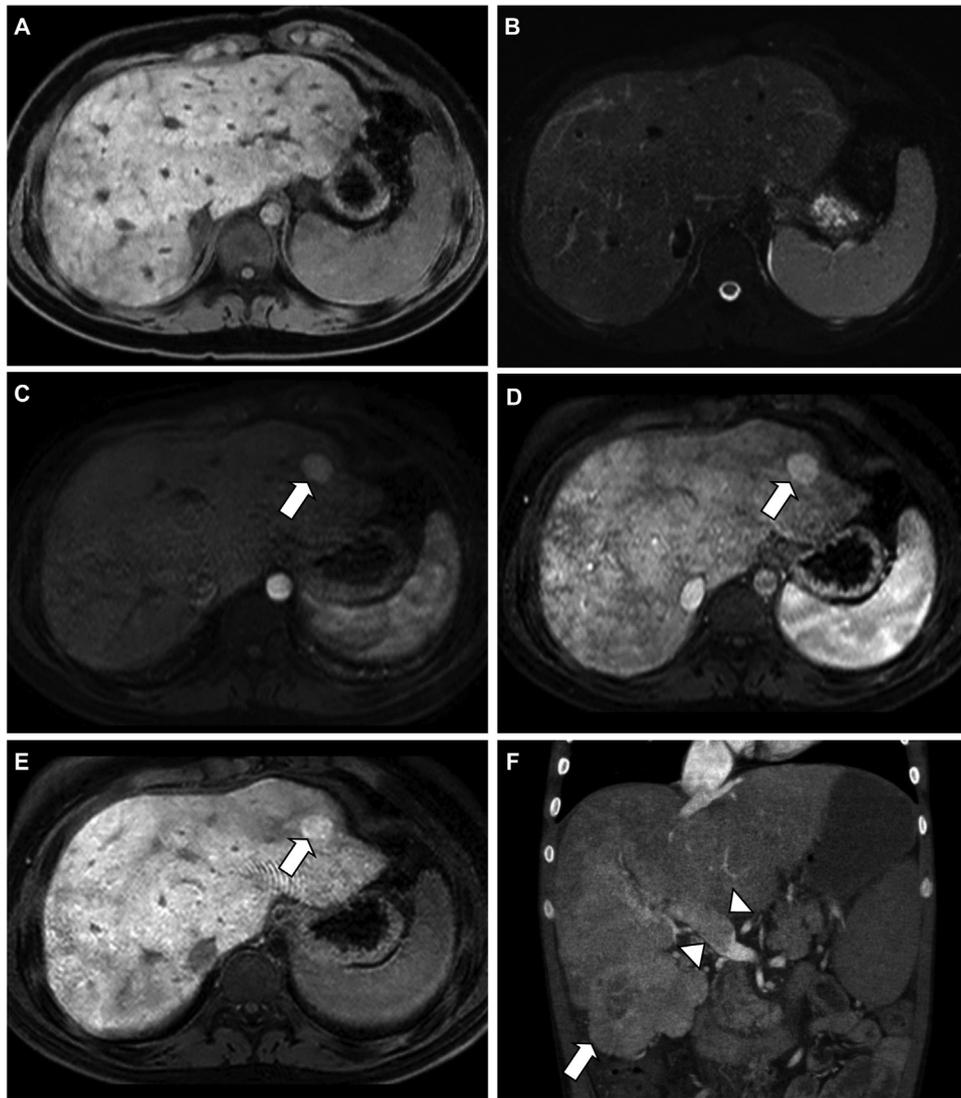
Example of hepatic nodules in Fontan-associated liver disease. Benign liver nodule (A–E). Pre-contrast T1-weighted magnetic resonance imaging (MRI) (A) and T2-weighted image (B) showing that the nodule is isointense to the surrounding parenchyma. Post-contrast (gadolinium) image shows that the nodule hyperenhances in the arterial phase (C) and remains hyperintense in the portal (D) and delayed hepatocyte (E) phases. These are the characteristics of a benign arterialized nodule. (E) Coronal view of T2-weighted MRI showing a hypervascular exophytic mass arising in the right lobe of liver (arrows). There is associated portal vein thrombus (arrow heads).
